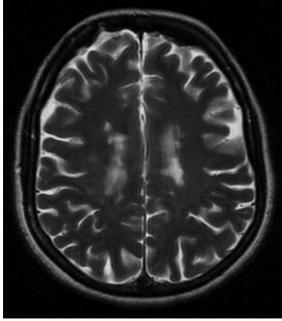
Magnetic resonance imaging (MRI). (A) Sagittal T2-weighted images. (B) Axial T2-weighted images. This shows multiple focal high-signal abnormalities characteristic of multiple sclerosis (MS). Such abnormalities, which are found in approximately 50% of patients with typical acute optic neuritis even if they have no history or physical evidence of other neurologic deficits, markedly increase the likelihood that a patient with optic neuritis will later develop clinically definite MS ("high-risk MRI"). (C) Axial T1-weighted MRI with contrast showing bilateral Optic Nerve (ON) enhancement due to bilateral optic neuritis.
